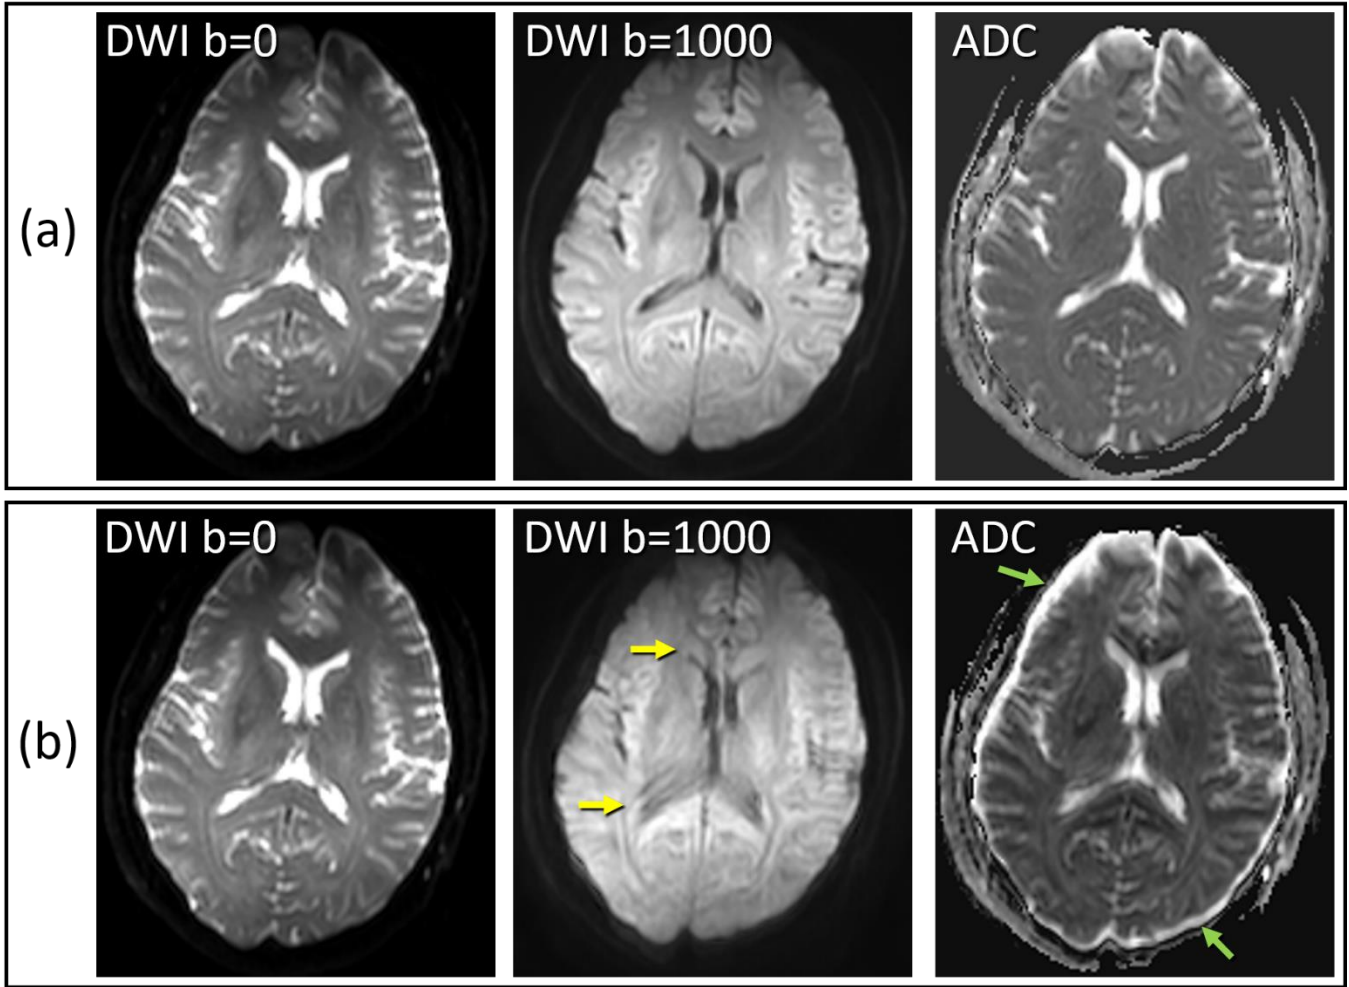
visual evidence of eddy currents in brain DWI. (a) Good quality DWI with no evidence of blur or spatial misalignment between low and high  $b$ -value DWI, thus no or low eddy current artifact. (b) Blur of anatomy on high  $b$ -value DWI (yellow arrows) relative to the  $b=0$  DWI, plus blur and exaggerated thickness of the CSF rind around the brain (green arrows) relative to the CSF space on  $b=0$  DWI are evidence of an eddy current artifact.
